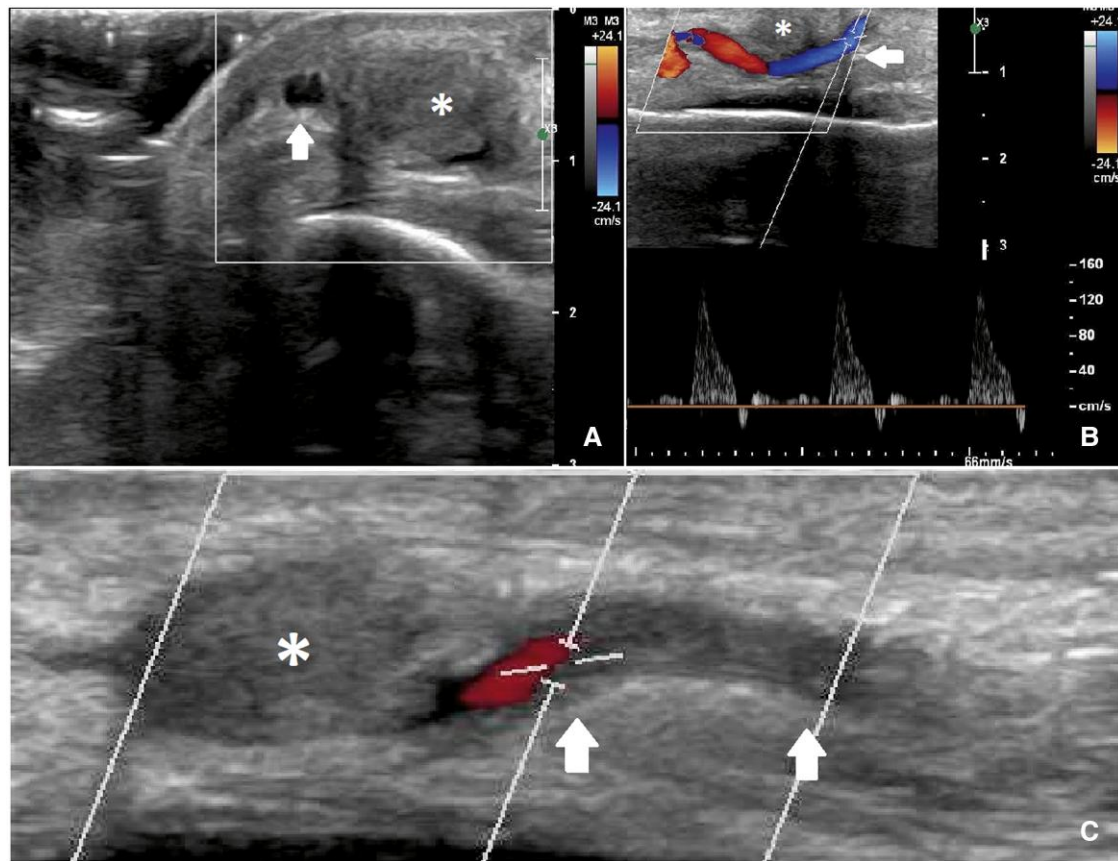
Sixty-day follow-up echo colour Doppler of the radial artery and the occluded pseudoaneurysm. Echo colour Doppler at 60 days showing both a short- (A) and long-axis views of the patent radial artery (B and C) with the pseudoaneurysm completely thrombosed. Asterisks indicate the pseudoaneurysm. Arrows point to the patent radial artery.
